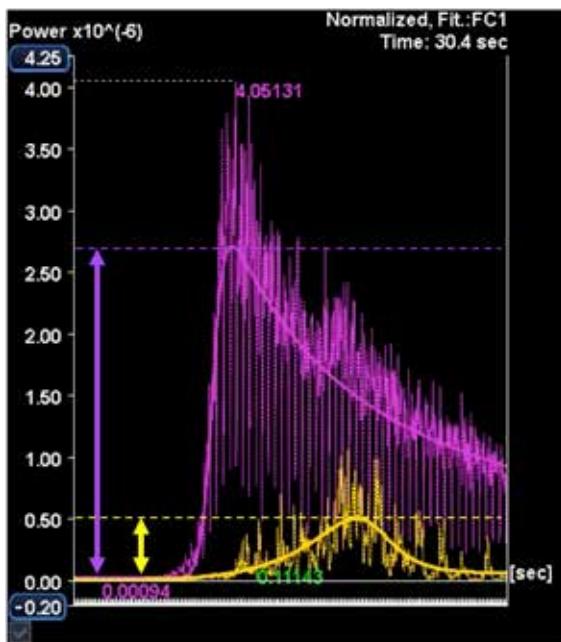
Time-intensity curve of contrast-enhanced ultrasonography.
